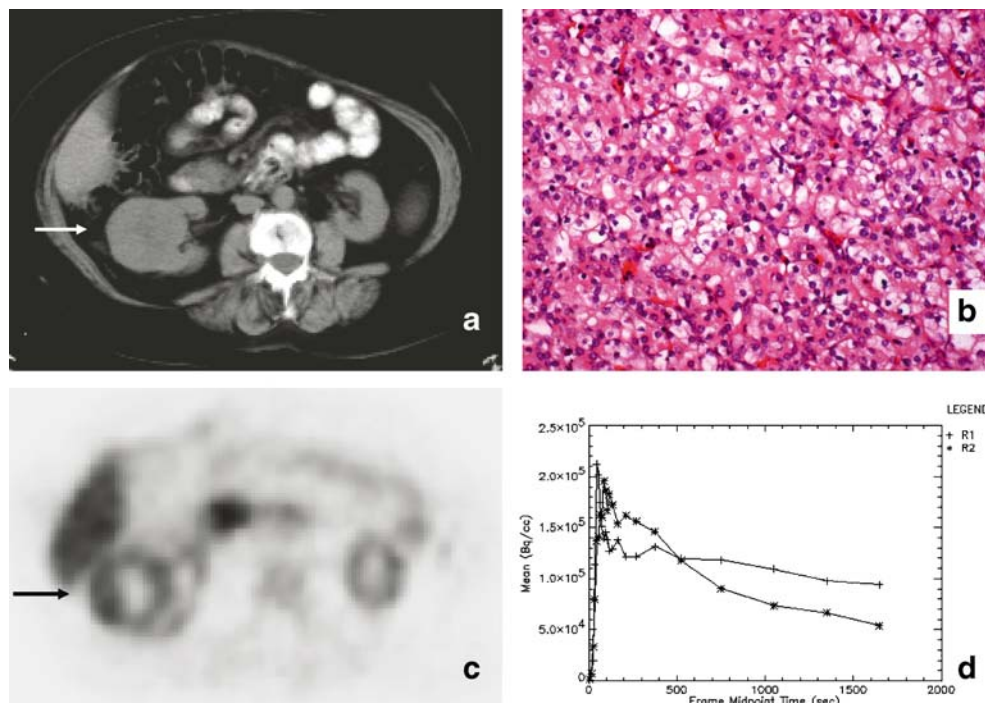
PET in a 66-year-old female (Table 1, patient no. 5) revealed a lesion of 60 mm in diameter in the right kidney (*white and black arrows*) with an AC uptake comparable to that in surrounding kidney parenchyma (score=2). Time-activity curve of the lesion (R1) yielded an initial peak and fast clearance comparable to normal kidney parenchyma (R2). Plain CT revealed a slightly inhomogeneous tumour
